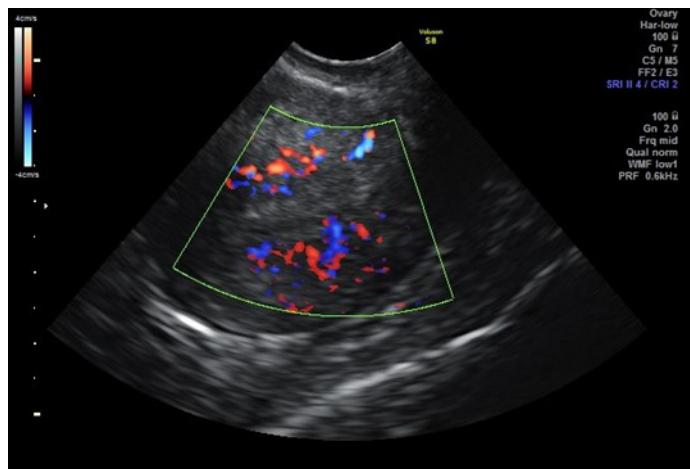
Ultrasound (Color Doppler) examination showed good sub-endometrial blood flow with adequate endometrial growth
